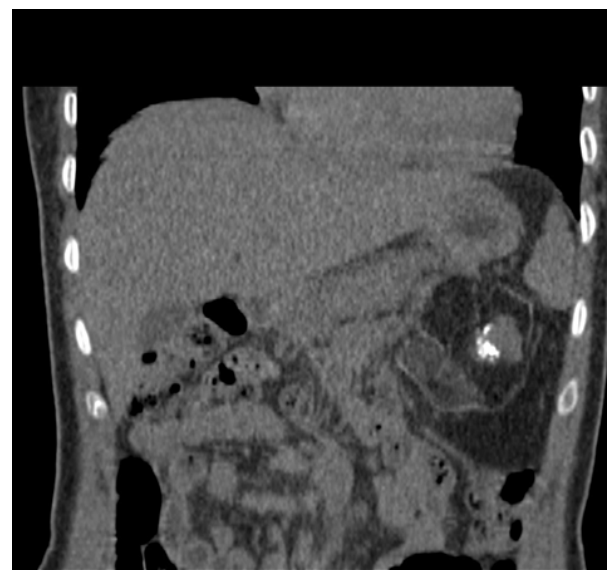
Coronal reconstruction of a CT scan passing through the upper abdomen in spontaneous contrast showing a retroperitoneal mass (arrow) containing multiple components, fatty, fleshy, and calcifications surrounded by a dense rim with a mass effect on the tail of the pancreas (asterisk).
